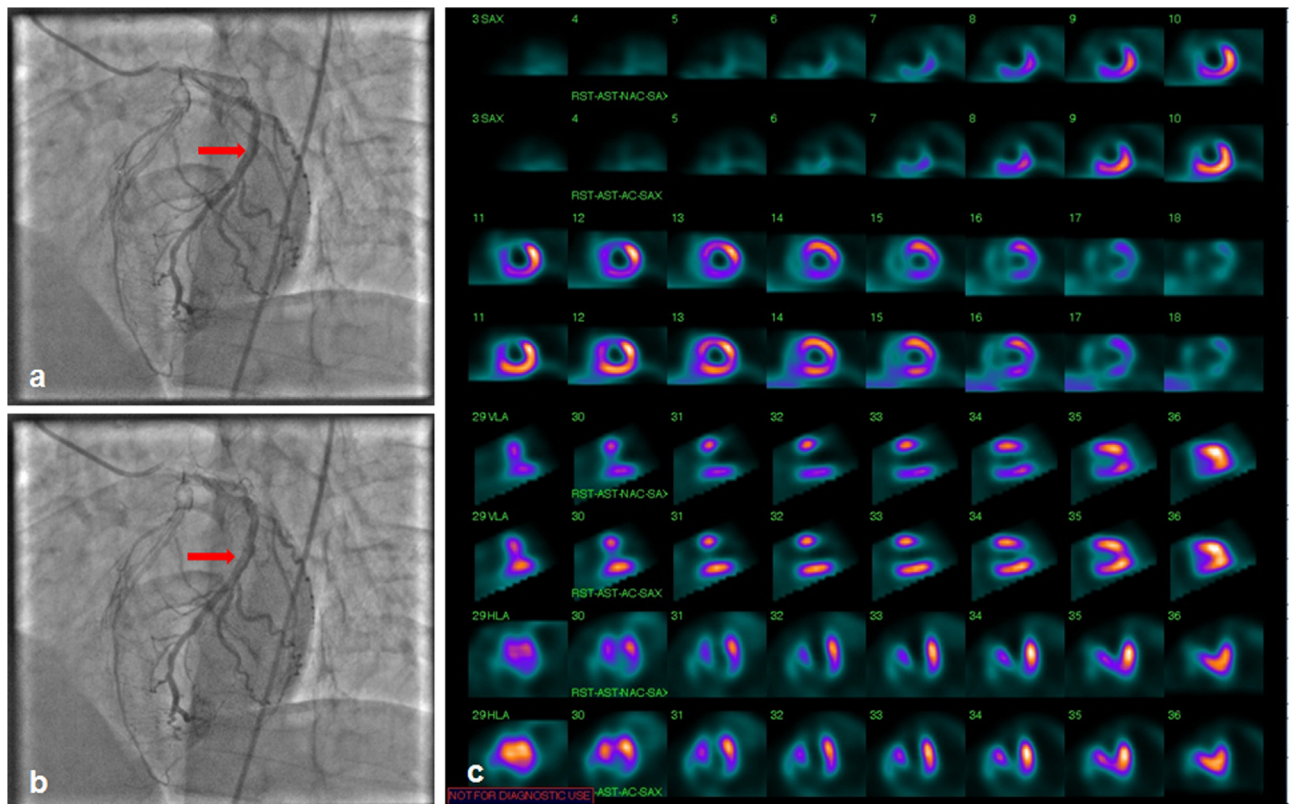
Coronary angiography in 52-years male showed radiolucency along the wall of the mid LAD suggestive of coronary artery dissection (a,b). Tc-99m sestamibi SPECT/CT MPI revealed non-viable apex, apical and adjacent mid anterior, parts of rest of the apical segments involving ~22–24% of the LV myocardium and predominantly viable mid & basal antero-septum and adjacent part of infero-septum involving ~14–16% of the LV myocardium (c).
